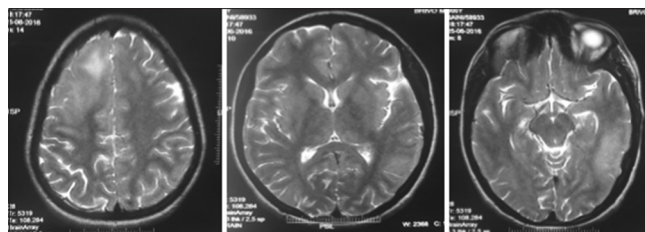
Magnetic resonance imaging brain showing – T2-weighted images showing bilateral white matter hyperintensity in parietal, temporal lobes
